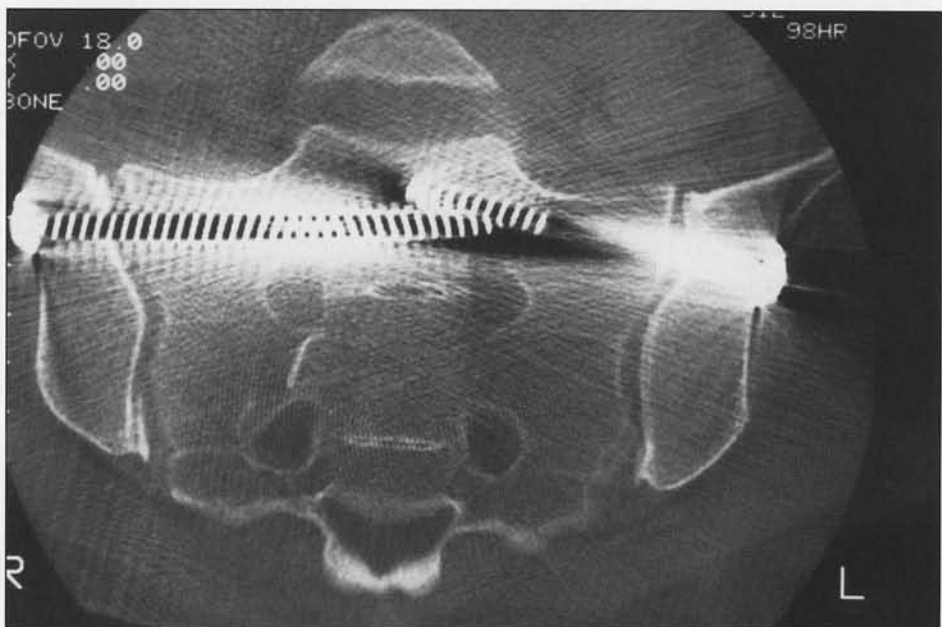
This postoperative CT scan demonstrates the almost perfect right sacroiliac and left sacral reductions as well as the implant safety. "Locking" the threads of opposite screws can be of benefit, especially in patients with poor bone quality.
